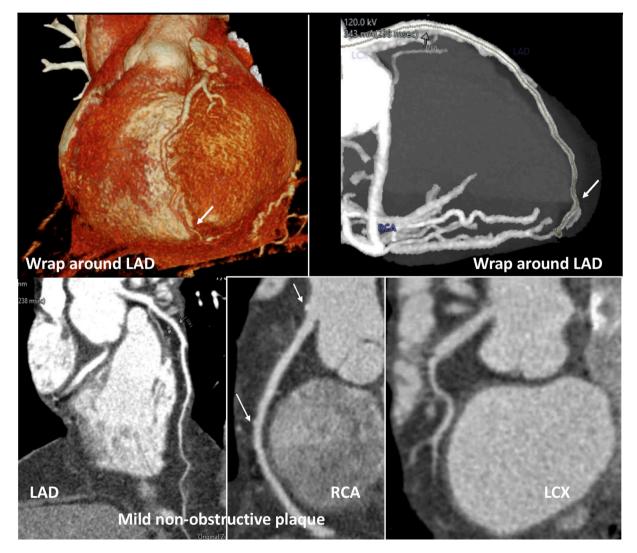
Minimal non obstructive coronary artery disease on Coronary CT Angiography, Multiplanar reformatted views of the right coronary artery (RCA), left anterior descending (LAD) and left circumflex (LCX). The coronary angiogram reveals minimal non-obstructive disease in the RCA and a wrap-around LAD with mild diffuse narrowing in the mid to distal LAD.
